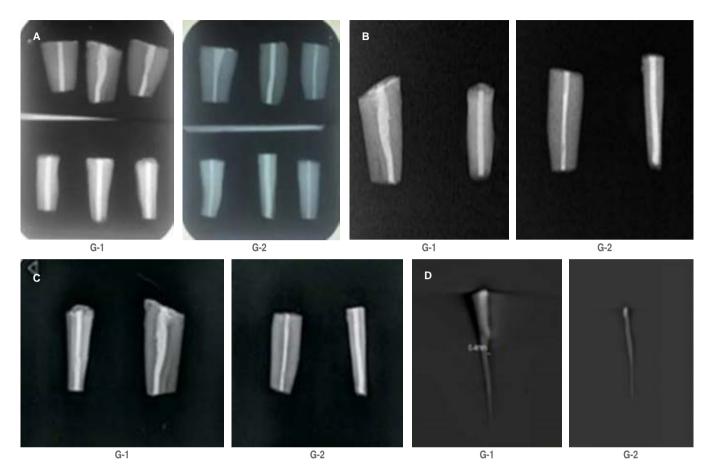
A) Images obtained by CX-ray. A representative image in mesiodistal and vestibule-palatal orientation by conventional radiography. G-1 (MA57) and G-2 (iRace) represent instruments employed in the lateral technique. A spaces inside obturation in G-1 is presented. G-2 reveals better obturation density. B) Images by SCX-ray. In the scanner, G-1 (MA57) and G-2 (iRace) images were obtained and evaluated for measurement obturation density by the lateral technique. In G-1, spaces inside of root canal were shown. In G-2, a better adaptation of the material is presented. C) Images by RGV. In the radiovisio-graphy (RVG) image of G-1 (MA57) and G-2 (iRace) obtained show in mesial-distal and vestibule-palatal planes. D) Image by CBCT. In these images obtained by Cone Beam computed tomography (CBCT) in three planes shows gutta-percha material inside of the root canal. In G-1 (MA57) a measurement of the space between the obturation material and the walls of the dentine was 0.4 mm. In G-2 (iRace 30), measurement was not possible.
